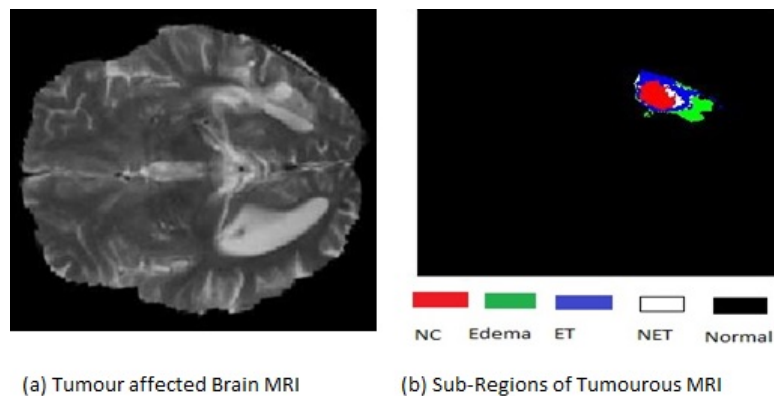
The Sub-Regions Present in a Tumour Affected Brain MRI
